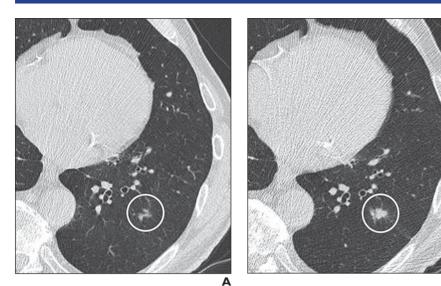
69-year-old man with history of head and neck cancer (squamous cell carcinoma) who was enrolled in lung cancer screening program. A, Low-dose CT image shows 6-mm solid nodule (*circle*) in left lower lobe. Nodule had slowly increased in size from prior imaging studies (not shown).
